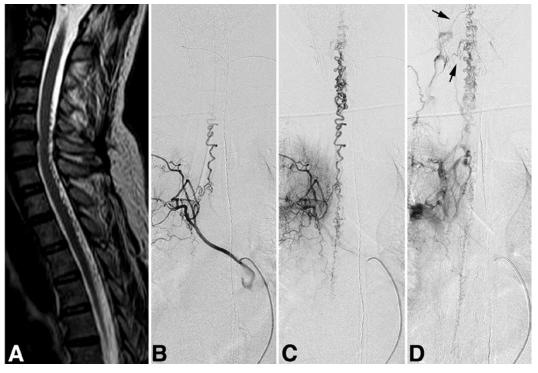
Case 10. Sagittal T2-weighted MR image (A) of the cervicothoracic spine demonstrating dilated perimedullary vessels from the C-4 to the T-4 level. There is no abnormal signal in the spinal cord. Anteroposterior angiograms of the right T-4 segmental artery revealing shunting of the right T-4 radiculomeningeal artery into a radicular vein (B), which drained mainly into cranially ascending as well as caudally descending perimedullary veins (C). The cranially ascending perimedullary veins opened to the external paravertebral plexus via the right C-2 and C-4 radicular veins (D, arrows).
